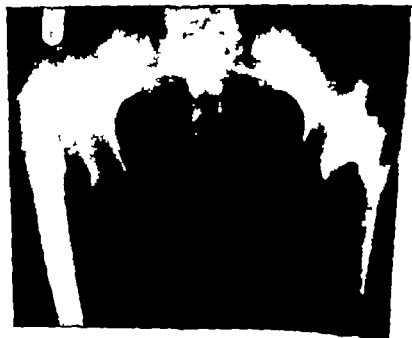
Radiograph showing an adult patient with an 'acetabular' hip of the hip on the right side and congenital subluxation of the left
